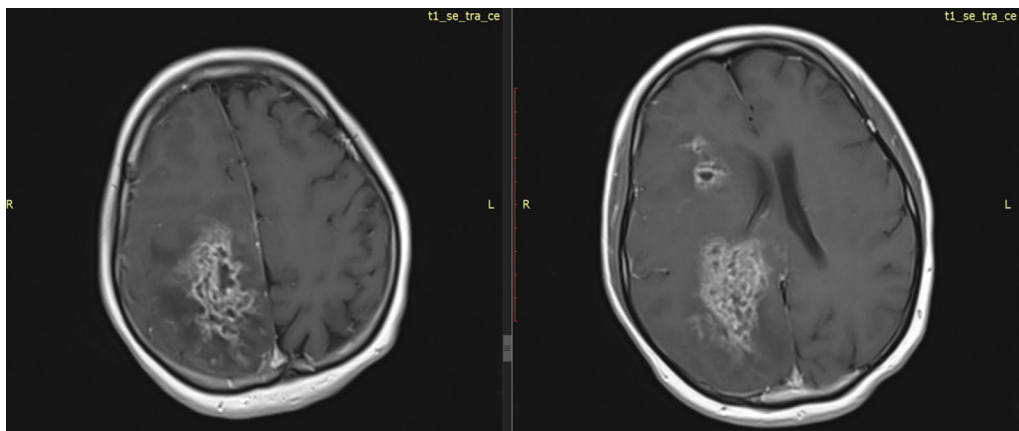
MRI post-contrast T1-weighted images of the brain shows multiple irregulars peripherally enhancing lesions with surrounding vasogenic edema. The images revealed an enhanced pattern of serpiginous tubular lesions resembling beads
